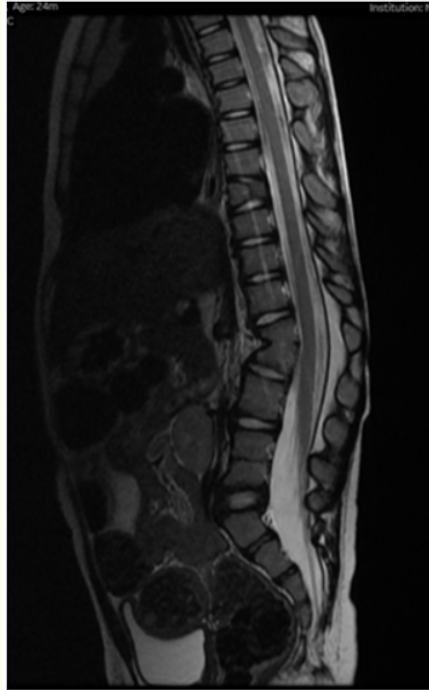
MRI spine taken at 2 years of age - The spinal cord is tethered, terminating at the level of L4. There is hemivertebra at the T9 level, fusion of the L1 and L2 vertebrae with a mild focal kyphosis at this level. Well as fusion of the L4 and L5 vertebrae.
